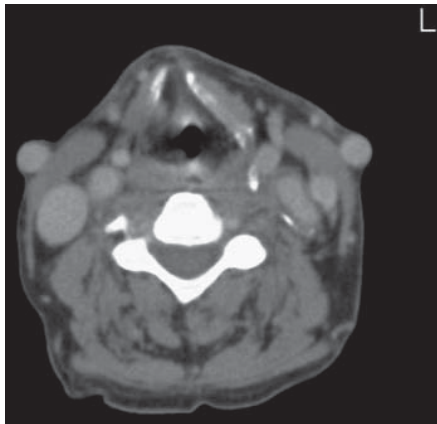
Post-operative CT revealing disappearance of gaseous laryngeal mass.
